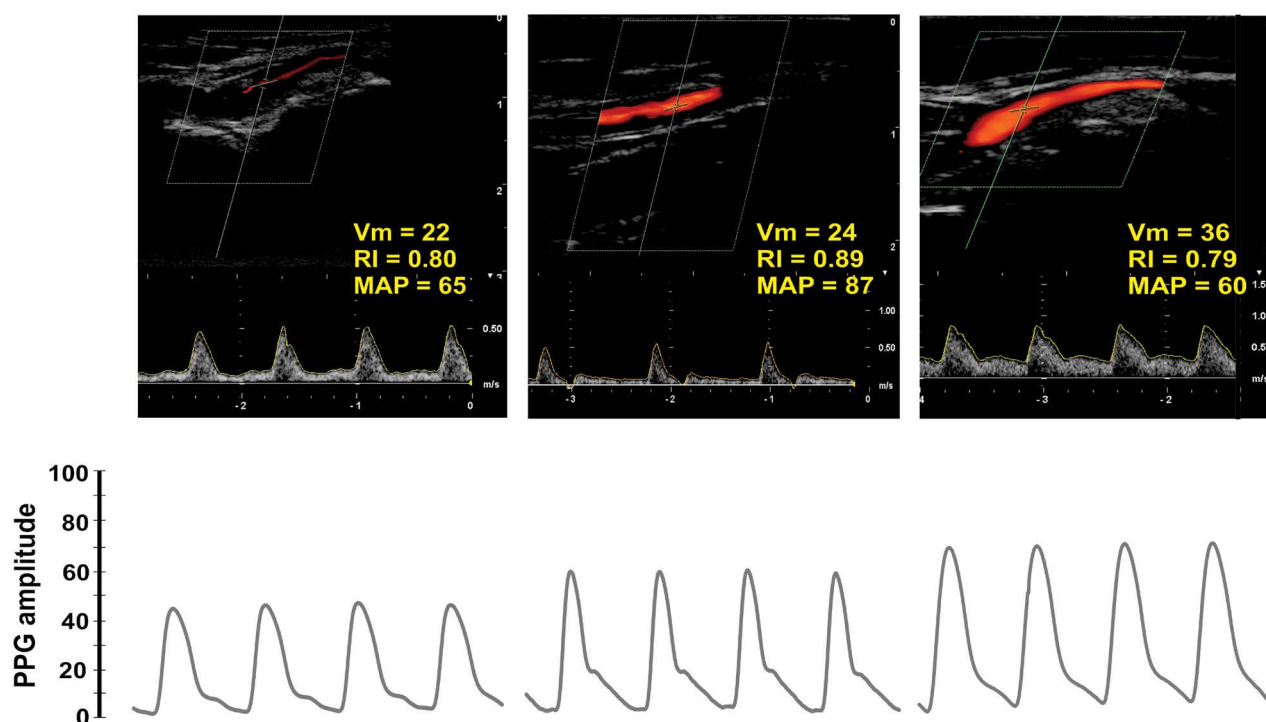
Duplex Doppler and photoplethysmography (PPG) in three different patients with normal mean arterial blood pressure (MAP).
